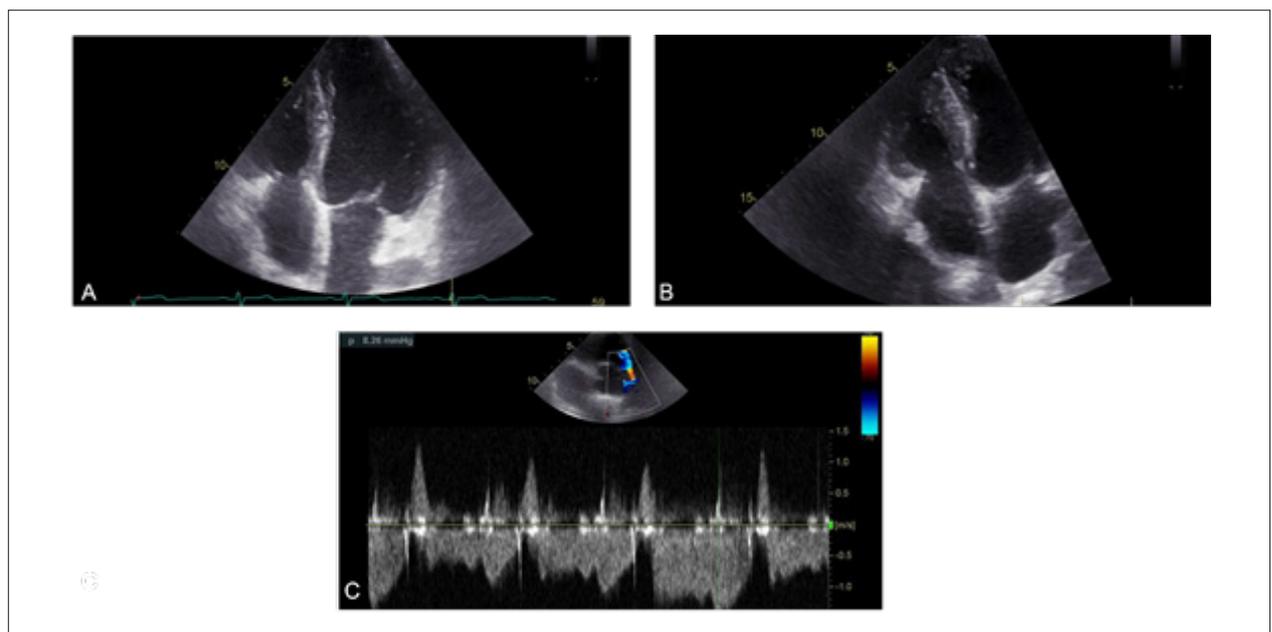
Two-dimensional transthoracic and transesophageal echocardiographic evaluation; A) apical four-chamber view in systole displaying an opened and retracted tricuspid valve, while the mitral valve is closed; B) apical four-chamber view in systole (focused on the right ventricle) displaying an opened and retracted tricuspid valve, while the mitral valve is closed; C) tricuspid flow curve, by continuous Doppler, showing a pressure equalization between the right atrium and ventricle.
